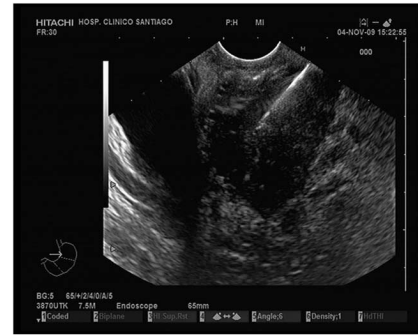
Endoscopic ultrasound image of a mass in the head of the pancreas. Fine needle aspiration of the mass confirmed the diagnosis of pancreatic adenocarcinoma.
